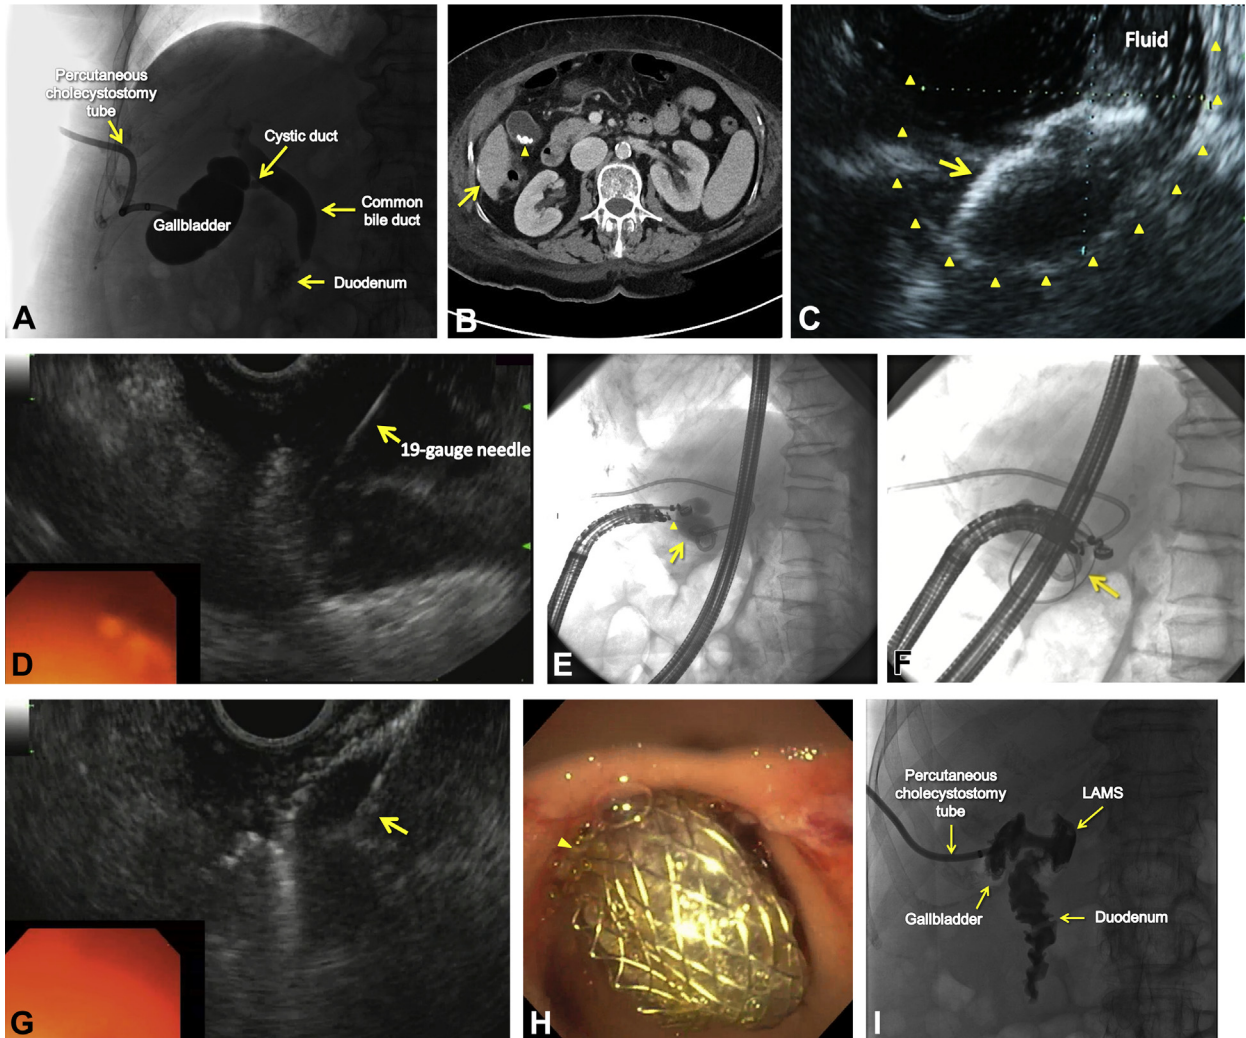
A, Preprocedural sinogram revealing opacification of the patent common bile duct with contrast material emptying into the duodenum. B, CT scan revealing gallbladder stones (*arrowhead*) and a cirrhotic liver (*arrow*). C, EUS view revealing a percutaneous cholecystostomy drain (*arrow*) in a distended gallbladder (*arrowheads*) with normal saline solution in its interior (*bubbles*). D, EUS view demonstrating the 19-gauge needle puncturing the gallbladder from the duodenum. E, Fluoroscopic view showing 19-gauge needle (*arrowhead*) and contrast material in the gallbladder (*arrow*). F, Fluoroscopic view revealing 3 loops of a 0.035-inch guidewire within the gallbladder (*arrow*). G, EUS view showing fully deployed distal flange of the stent (*arrow*) within the gallbladder. H, Endoscopic view showing the proximal flange of the lumen-apposing metal stent (LAMS) deployed in the duodenal bulb (*arrow*). Bile can be appreciated flowing through the catheter (*arrowhead*). I, Fluoroscopic view revealing contrast material flowing through the percutaneous cholecystostomy tube into the gallbladder and into the duodenum, further confirming adequate stent placement.
